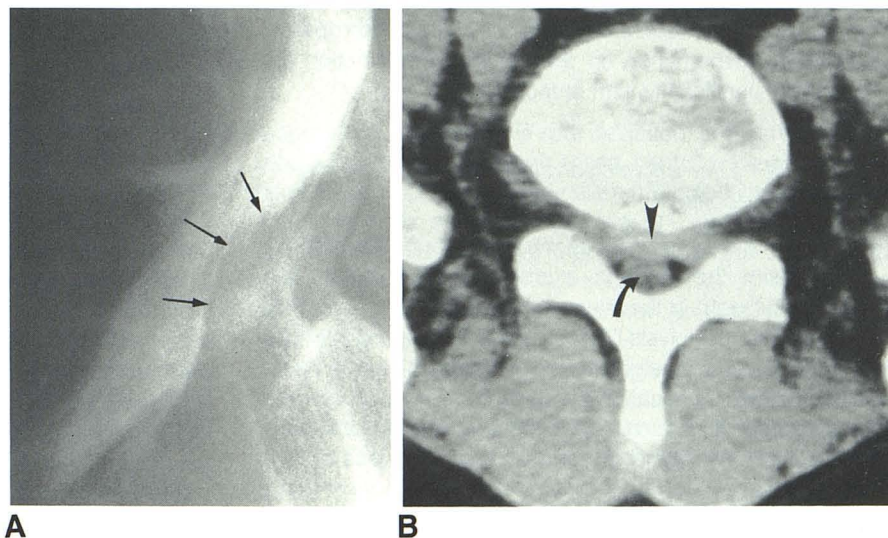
45-year-old man with unsuccessful chymopapain chemonucleolysis. Surgery confirmed L5–S1 disk herniation with free fragment 3 weeks after treatment. A, Myelogram. Extradural compression of thecal sac centered at L5–S1 interspace but extending above and below (arrows) level of disk space. B, CT scan confirms L5–S1 disk herniation (arrowhead) displacing thecal sac (arrow) posteriorly.
